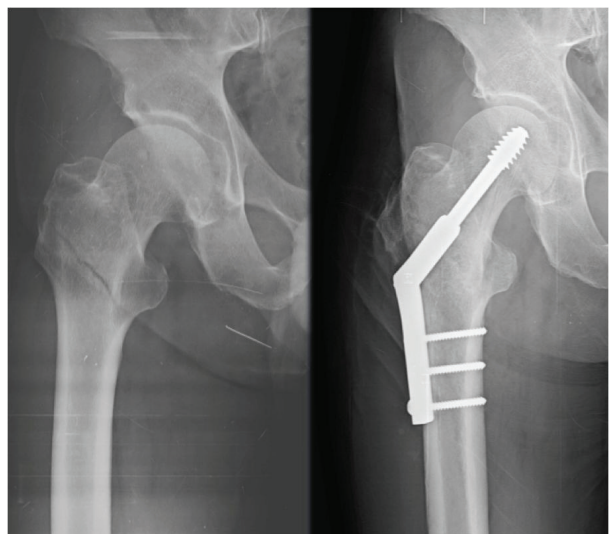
Pre- and post-operative AP X-ray of an 81-year-old patient with stable intertrochanteric femur fracture that was treated with DHS
